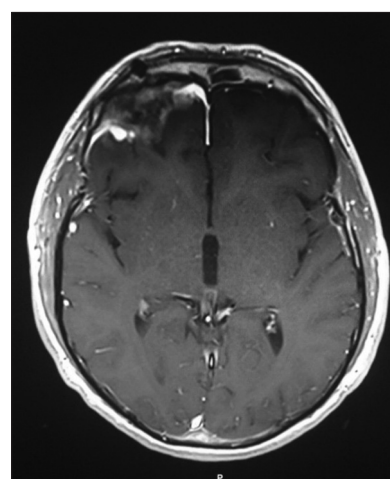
Axial T1-weighted magnetic resonance image post-gadolinium showed total resection of the tuberculoma with postoperative changes.
